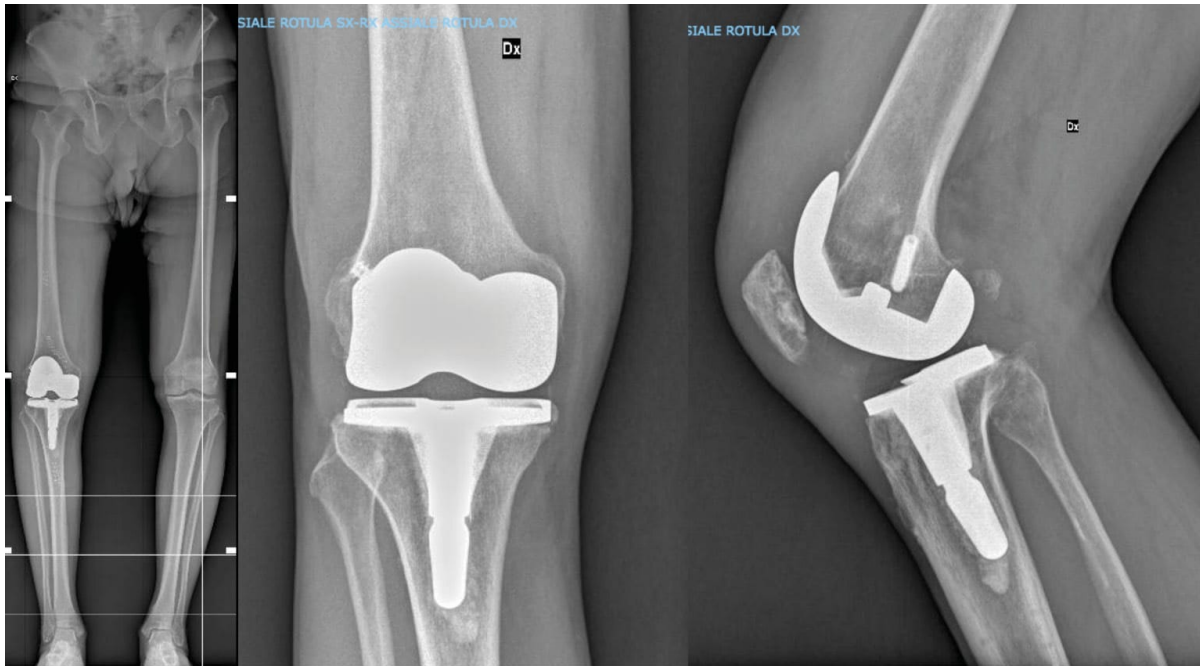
Postoperative X-rays of the same patient from Figure 1 and Figure 2. A Persona® implant (Zimmer Biomet, Warsaw, IN, USA) with a Posterior-Stabilized insert and a 14 × 30 mm tibial stem was used. The tibial fixation device was removed, while the femoral fixation device was left in place.
